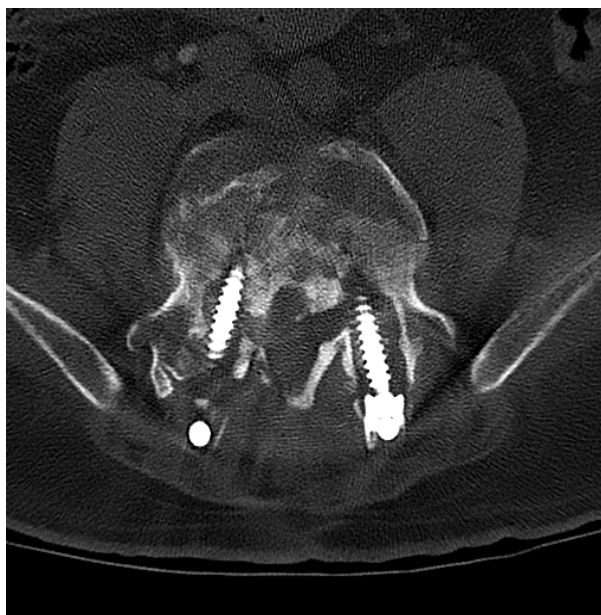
Post-operative infection with screw loosening. Axial CT scan (bone window with OMAR software) showing marked osteolysis due to severe post-operative infection with marked loosening of both fixing screws.
